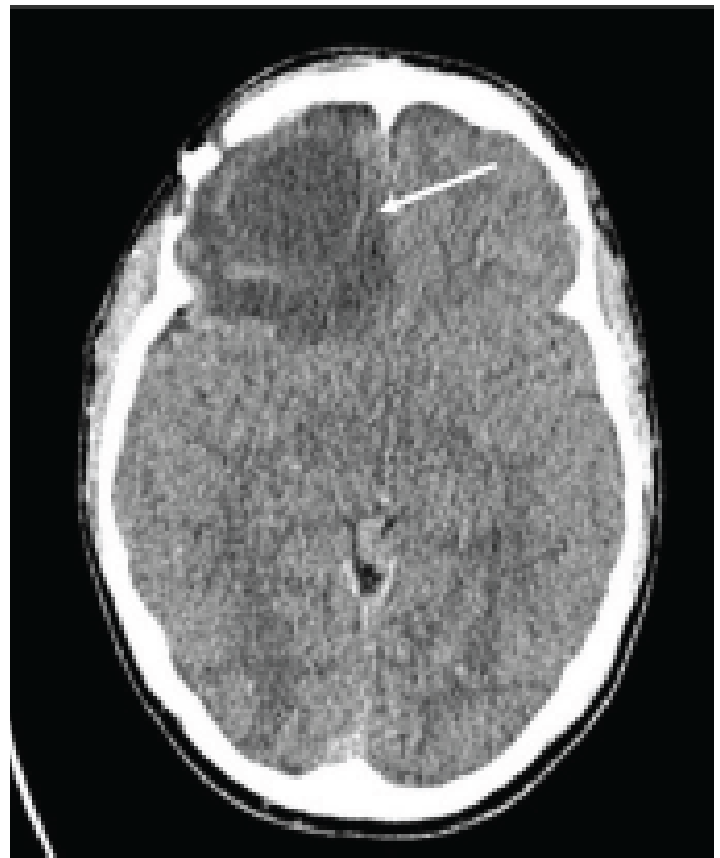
On the patient's second emergency department visit for recurrence of symptoms, head computed tomography demonstrated interval development of a hypodense focus with hyperattenuating rim, concerning for a recurrent organizing intraparenchymal abscess with two millimeters leftward midline shift (arrow).
